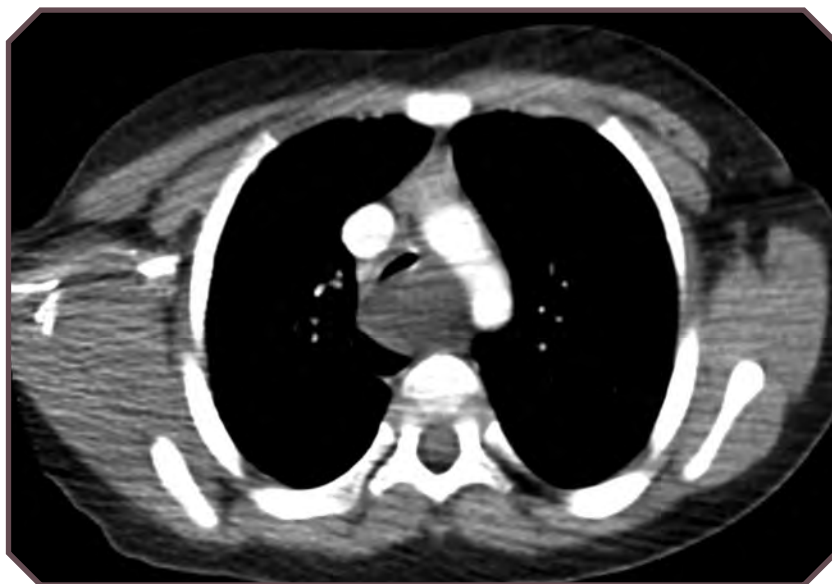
Axial contrast-enhanced computed tomographic image obtained in a 17-month-old girl with a bronchogenic cyst shows a fluid-filled mass of the middle mediastinum centered at the level of the trachea and aortic arch above the carina, with right posterolateral displacement of the esophagus by the cyst. Image courtesy of Robert Paul Guillermin, MD, Pediatric Radiology, Texas Children's Hospital.
